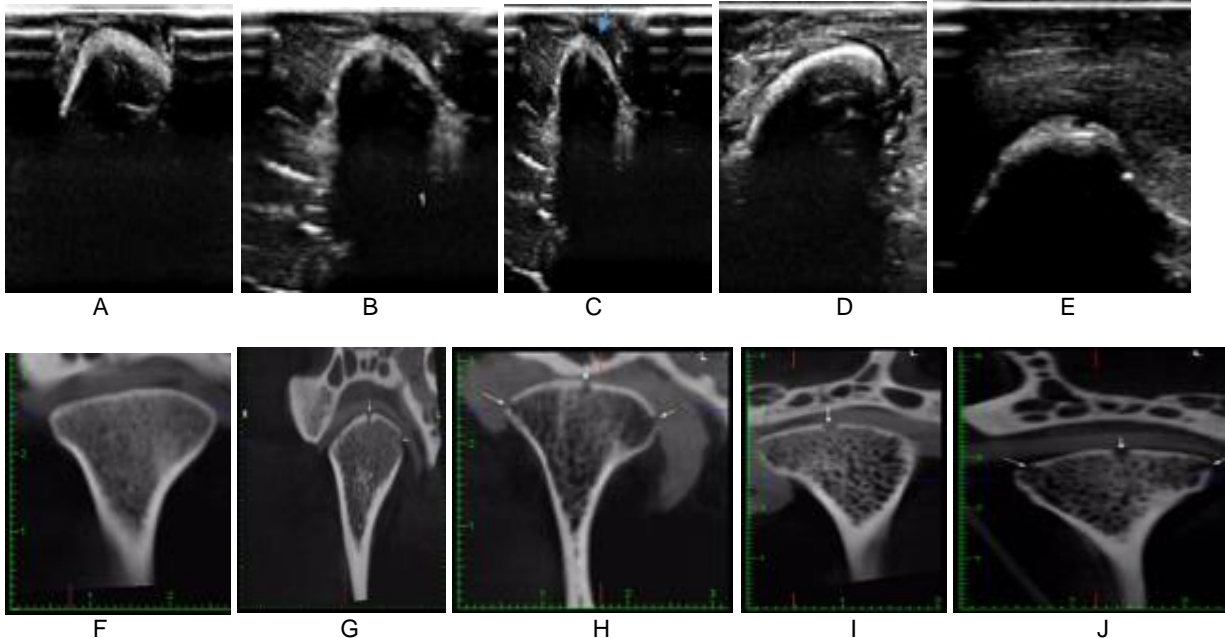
Ultrasound images from TMJs. a: no defect, b:0.5mm defect, c:1mm defect, d:1.5mm defect, e :2mm defect
